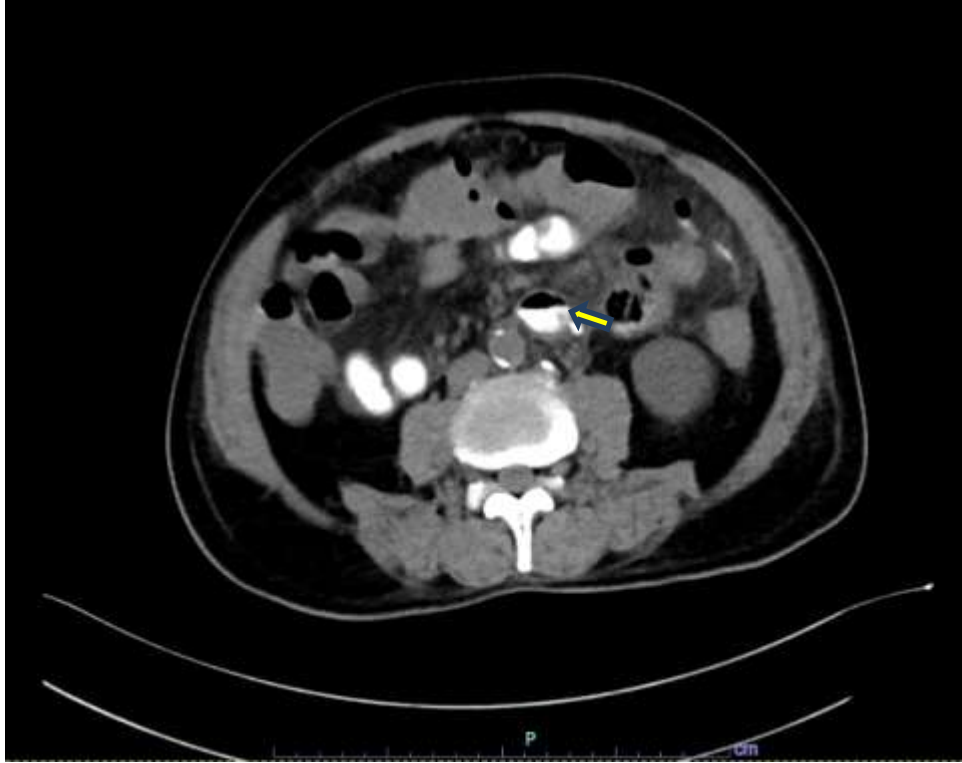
Jejunal diverticula seen on CT Scan abdomen dated 28-04-2023.
